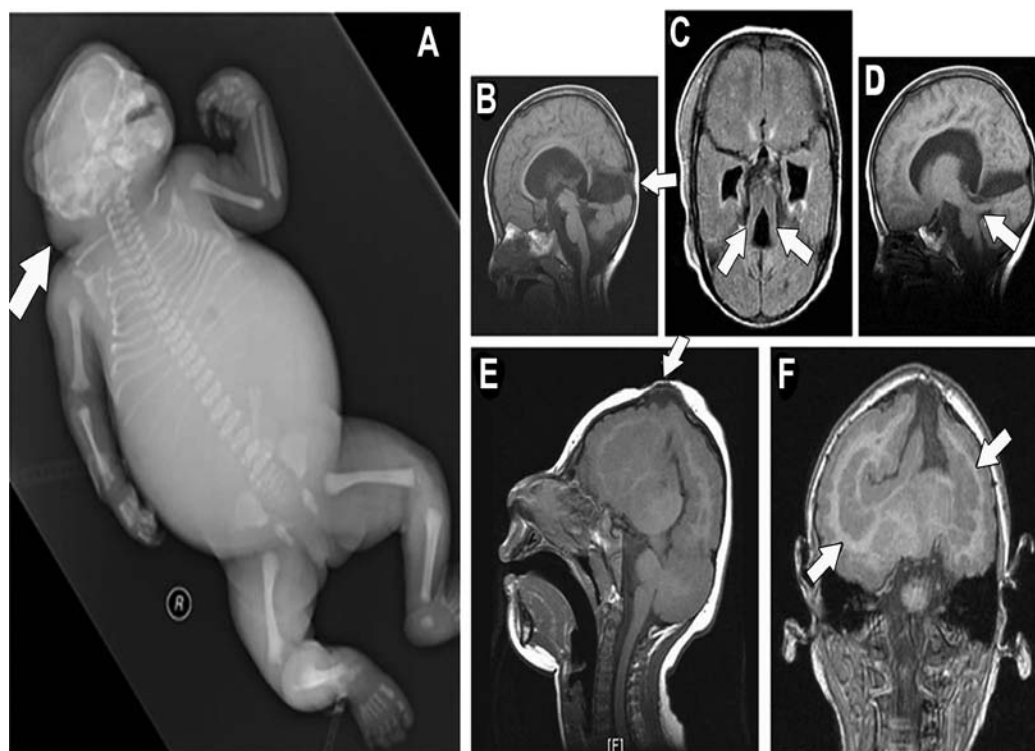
Images showing: A) posterior encephalocele (arrow) seen in an x-ray carried out on a newborn who had Meckel-Gruber syndrome. The abdomen is distended due to associated polycystic kidneys. Polydactyly of the right foot is also shown; B, C, & D) MRI features of a child who had Joubert syndrome associated with posterior encephalocele. Note the osseous defect of the cranium (arrow, B); C) axial image at the level of midbrain shows the classic “molar tooth sign” with the roots of the tooth formed by the thick and horizontally oriented superior cerebellar peduncles (arrows); D) parasagittal image demonstrating a thick and horizontally oriented superior cerebellar peduncle (arrow); E & F) holoprosencephaly; E) sagittal MRI image showing an associated encephalocele (arrow); and F) coronal image revealed fusion of the cerebral hemispheres, associated with band heterotopias (arrows).
